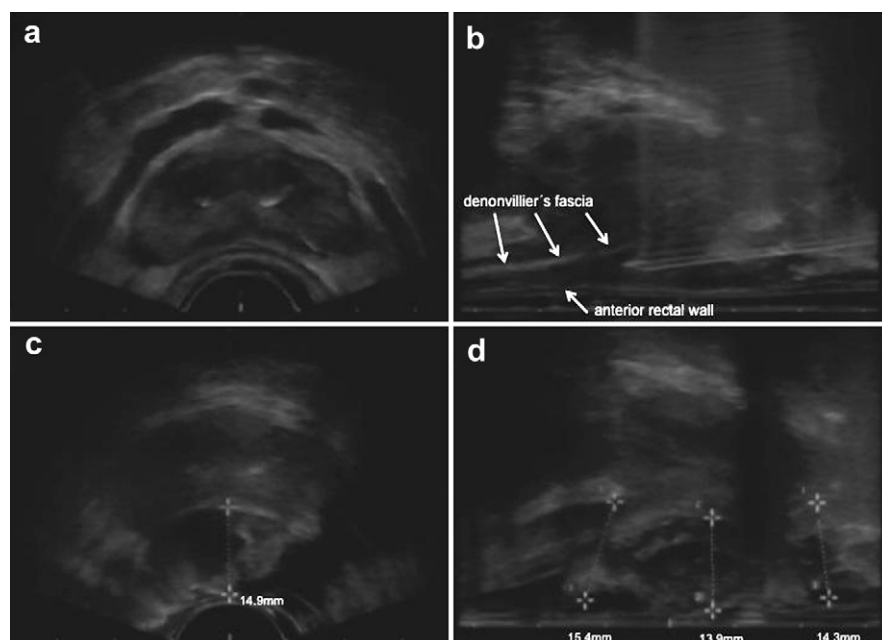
Transrectal ultrasound images of prostate before (a) and after (c, d; axial and sagittal) hydrogel injection and (b) showing hydrodissection to open up the space between Denonvilliers' fascia and anterior rectal wall.
